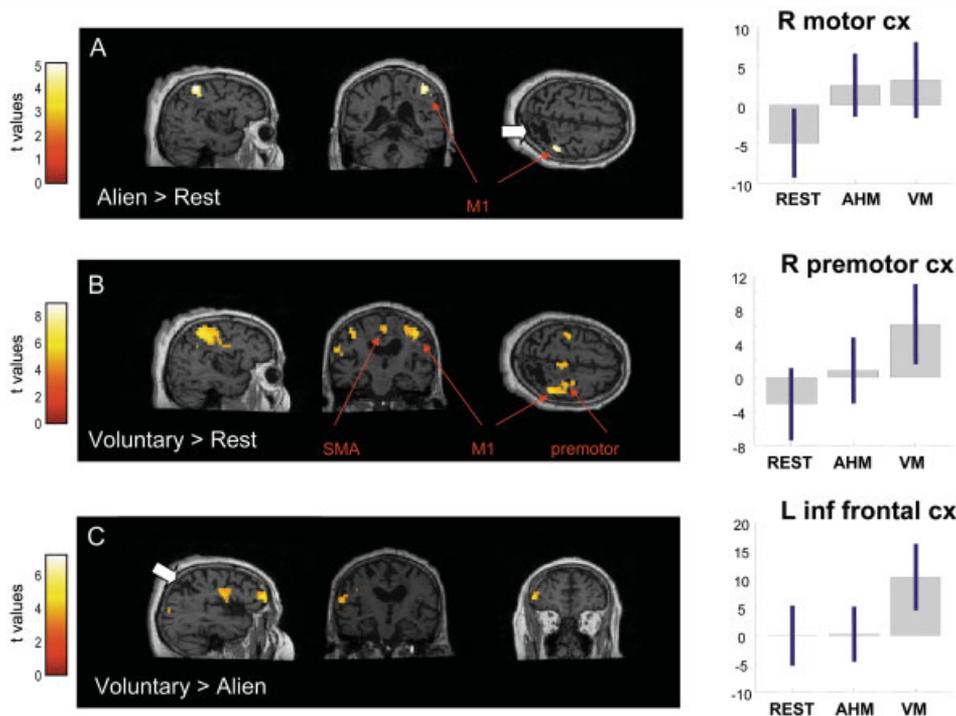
Brain areas activated in the first functional magnetic resonance imaging scan during (A) periods with alien movements of left hand (AHMs), relative to actual rest; (B) periods with voluntary movements (VMs) of left hand, relative to actual rest; or (C) periods with voluntary relative to alien movements of left hand. (right) Parameters of activity are plotted for regions of interest across these different conditions. Whereas M1 was activated similarly during voluntary or alien movements, right premotor and left prefrontal areas were activated selectively during voluntary movements. White arrows indicate right parietal lesion. SMA = supplementary motor area.
